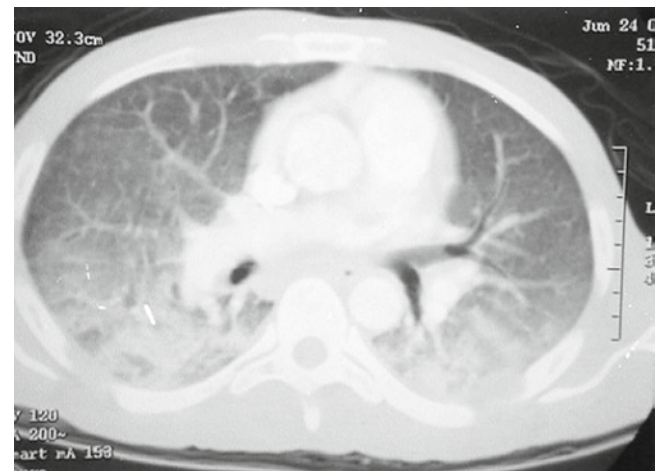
CT showing severe bilateral cryptococcal lobar pneumonia and prominent adenopathy in an AIDS patient
